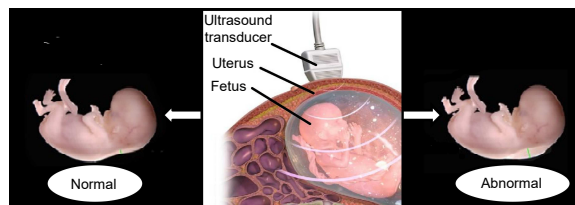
Nuchal translucency detection by ultrasound scan.
